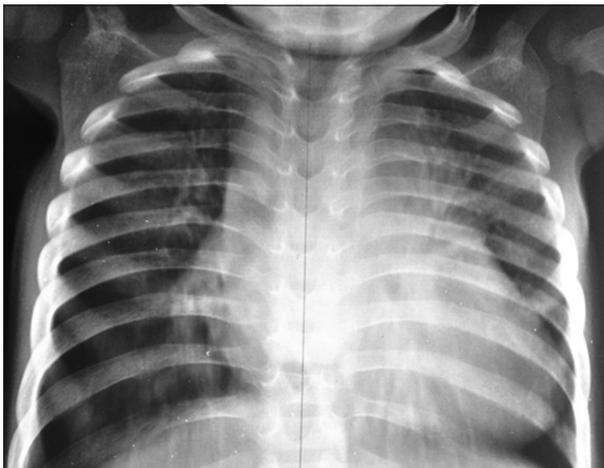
Chest X-ray showing cardiomegaly at the expense of the right cavities and vascular redistribution to the apices
